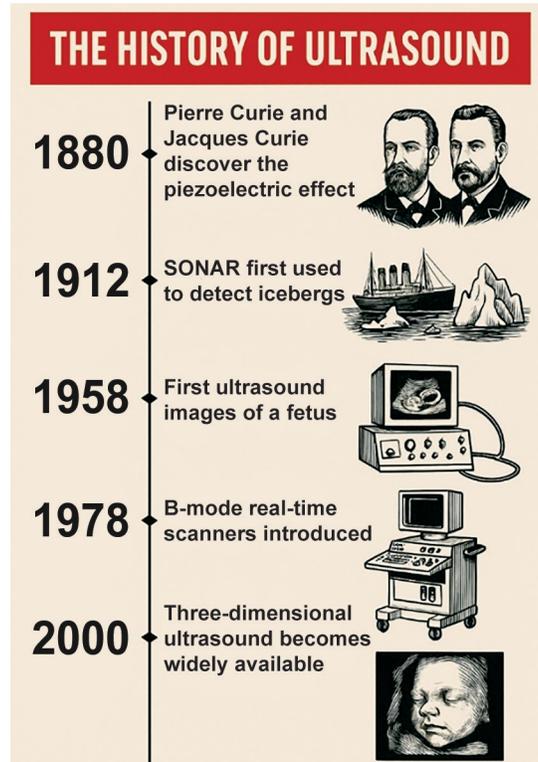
History of ultrasound
